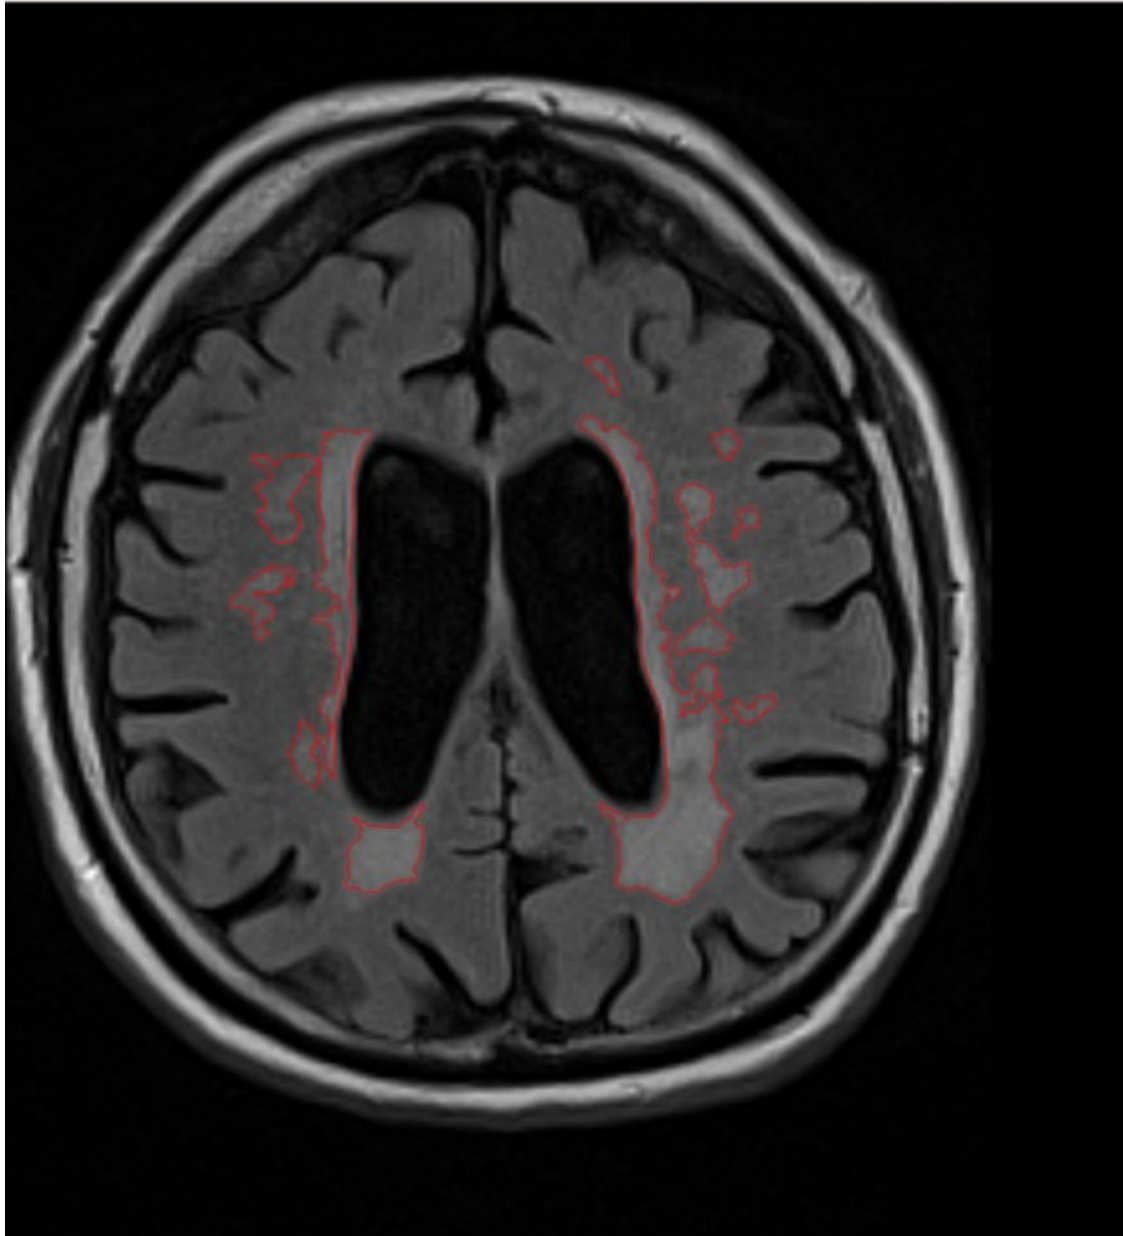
Axial FLAIR slice of one study individual. Periventricular WMH inflate into deep white matter and confluence with deep WMH. Reused from our PLOS One publication (Birner et al., 2015).
